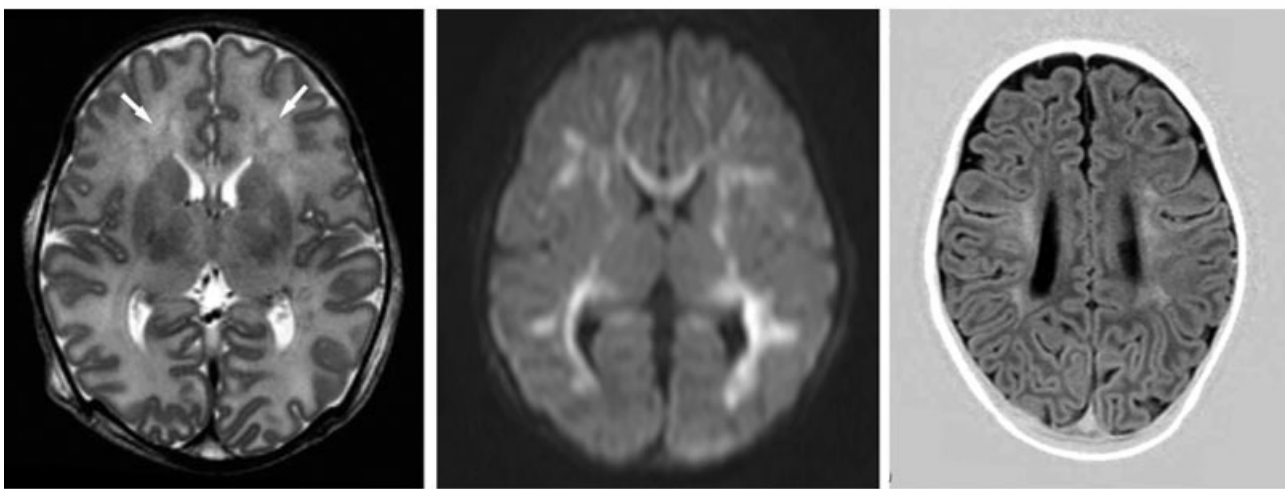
Magnetic resonance imaging (MRI) T2-weighted spin-echo sequence (left), diffusion-weighted imaging (middle) 6 days after the onset of human parechovirus (HPeV) infection, and inversion recovery sequence (right) at 3 months of age (Patient 7). Note multiple punctate white matter lesions (arrows) (left) and diffuse excessive high signal intensity in the periventricular white matter, involving the optic radiation and the internal capsule (middle), and periventricular high signal intensity changes suggestive of early gliosis in the periventricular white matter at 3 months of age (right).
